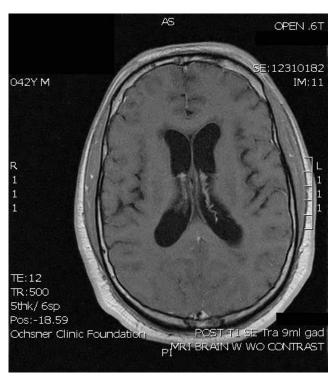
Magnetic resonance imaging showing development of hydrocephalus after 19 cycles of pemetrexed.
